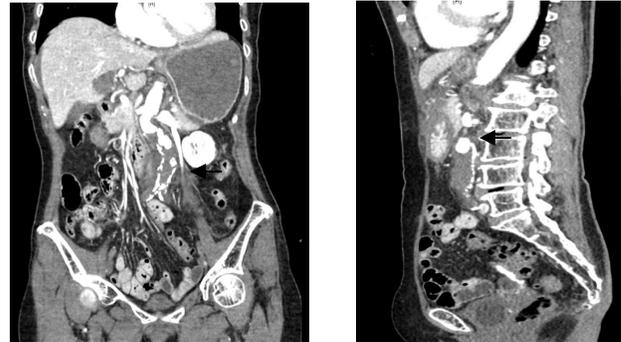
CT abdomen shows aortic dissection
